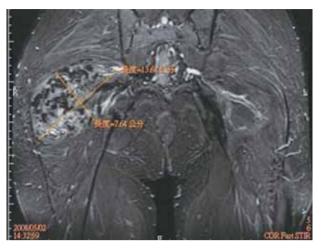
A large mass is shown within the gluteus maximus muscle with a high signal on T2-weighted magnetic resonance imaging (MRI) indicating enlarged venous compartments. The greatest dimension was more than 13 cm. Tubular structures with low signals indicate fast voiding vessels.
